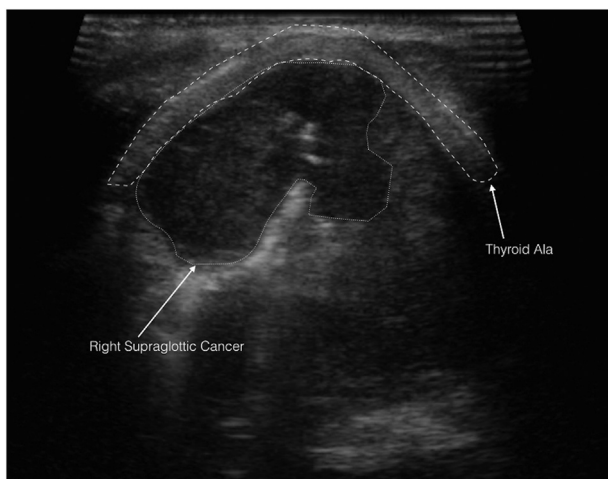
Transverse ultrasound of a midline neck showing a right supraglottic cancer. Beneath the thyroid lamina (dashed line), a large hypoechoic right supraglottic lesion is seen filling the false vocal fold and extending across midline (dotted line).
